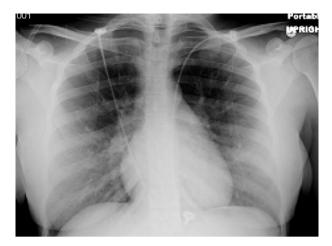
Initial chest radiograph showing diffuse interstitial infiltrates and minimal pulmonary vascular congestion.
